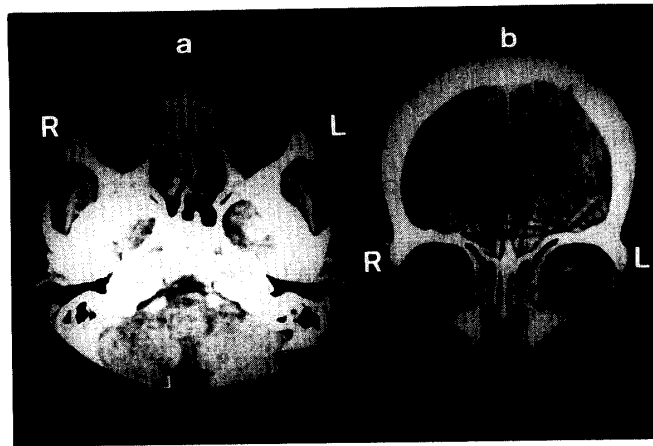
On March 11, 1988, axial (a) and coronal (b) computed tomography scans demonstrate high densities in both orbits.
